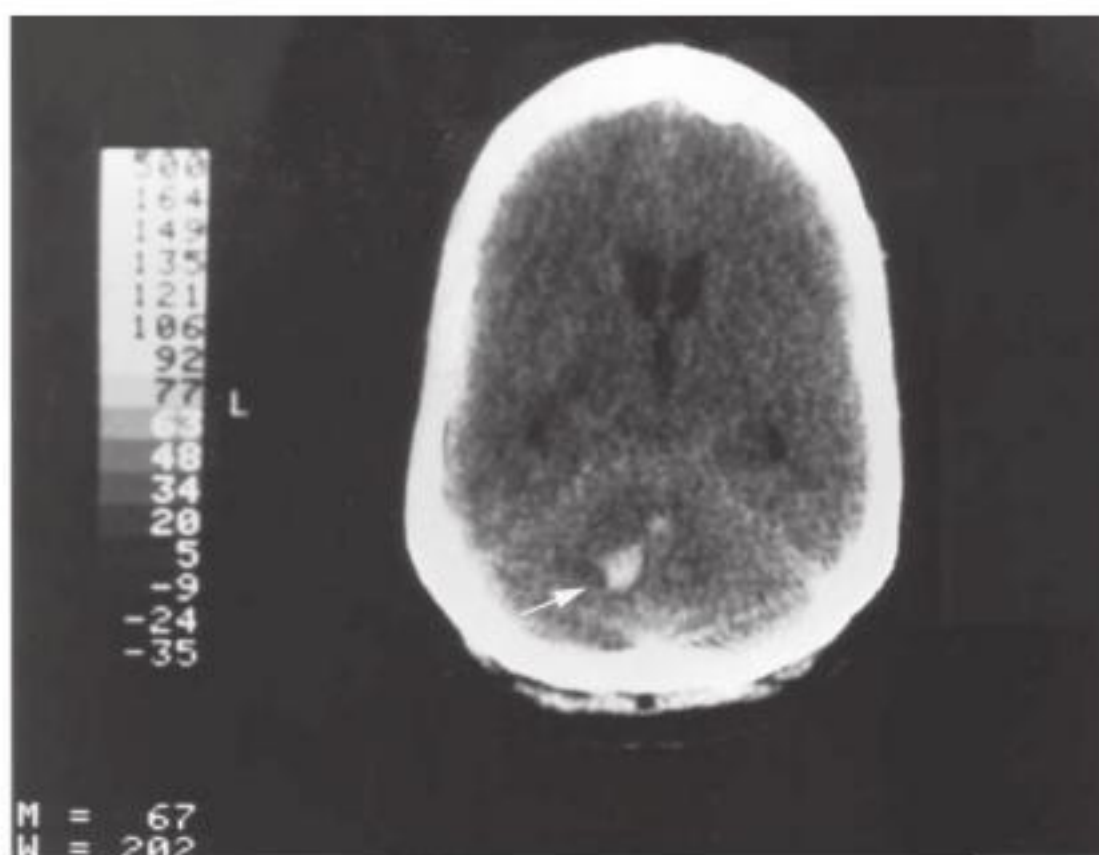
CT scan of Tom M. showing a left cerebellar hemorrhage. The hemorrhage appears white (white arrow points to the hemorrhage).
